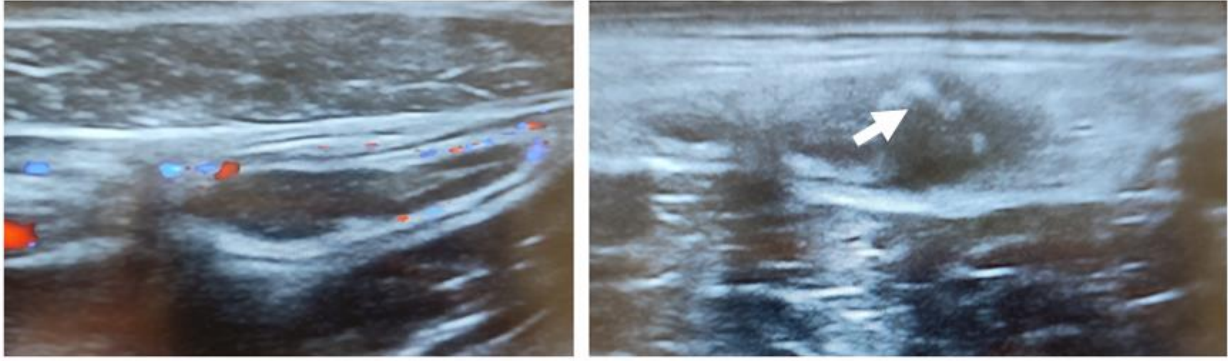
Ultrasound showing dilated incompressible appendix with appendicolith and hyperemia
